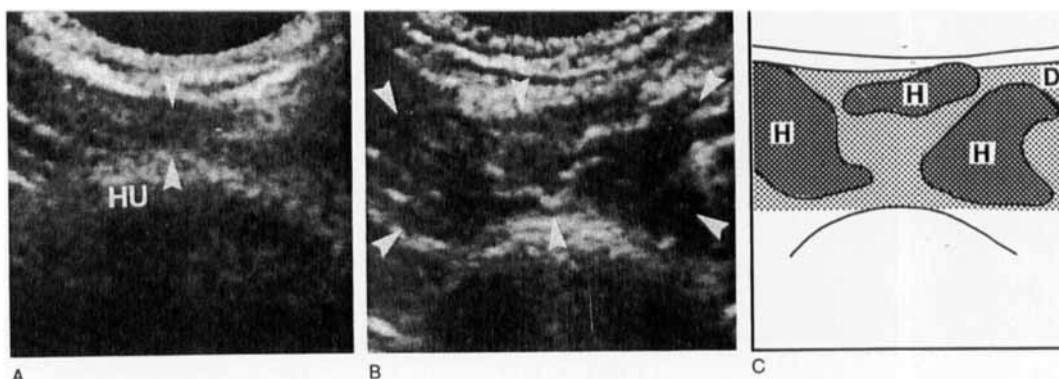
A. Normal sonogram showing deltoid muscle (arrowheads) and humerus (HU). B and C. The deltoid muscle (D) enlarged with relatively well-delineated echo-poor areas (arrowheads and H) representing hematoma (H).
